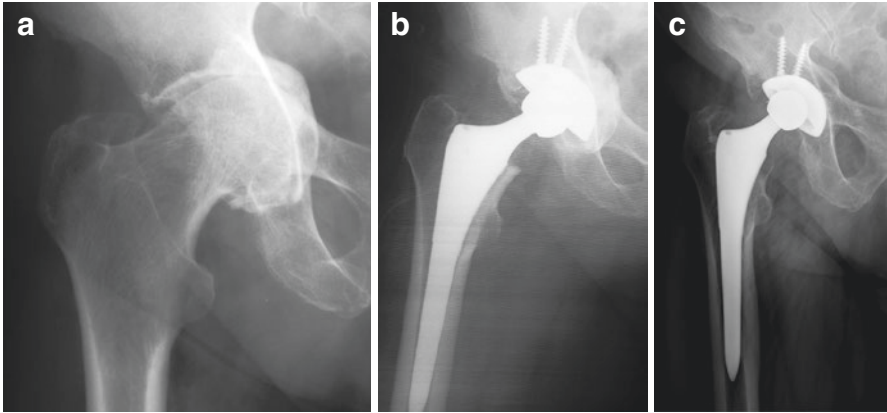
(a) Anteroposterior radiograph of a hip shows acetabular protrusion. (b) Postoperative radiograph, a cancellous autograft taken from the femoral head was used to reconstruct the acetabular protrusion. (c) Postoperative radiograph at 10 years shows good trabecular remodelling of the autograft
